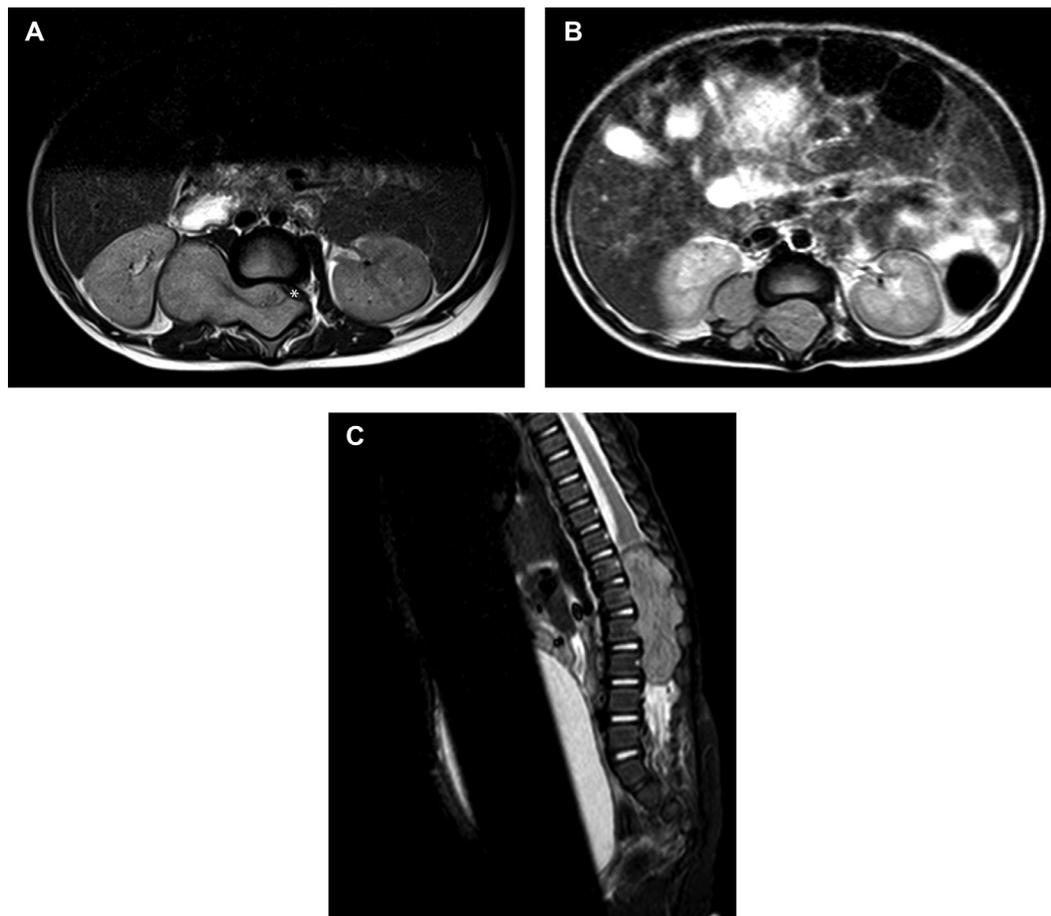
Invasion of the spinal canal, consistent with the presence of an IDRF (L2). (A) Axial T2-weighted MR image in a 1-year-old girl with retroperitoneal neuroblastoma shows intraspinal extension involving more than one-third of lumbar spinal canal, with no leptomenigeal spaces visible and with displacement and compression of the spinal cord (*). (B) Axial T2-weighted MR image in a 1-month-old girl with a retroperitoneal mass with intraspinal extension filling the entire canal and obliterating visualization of the cord at that level. (C) Sagittal T2-weighted MR image in same patient as in (B) shows complete filling of the spinal canal with tumor. Note distended bladder.
